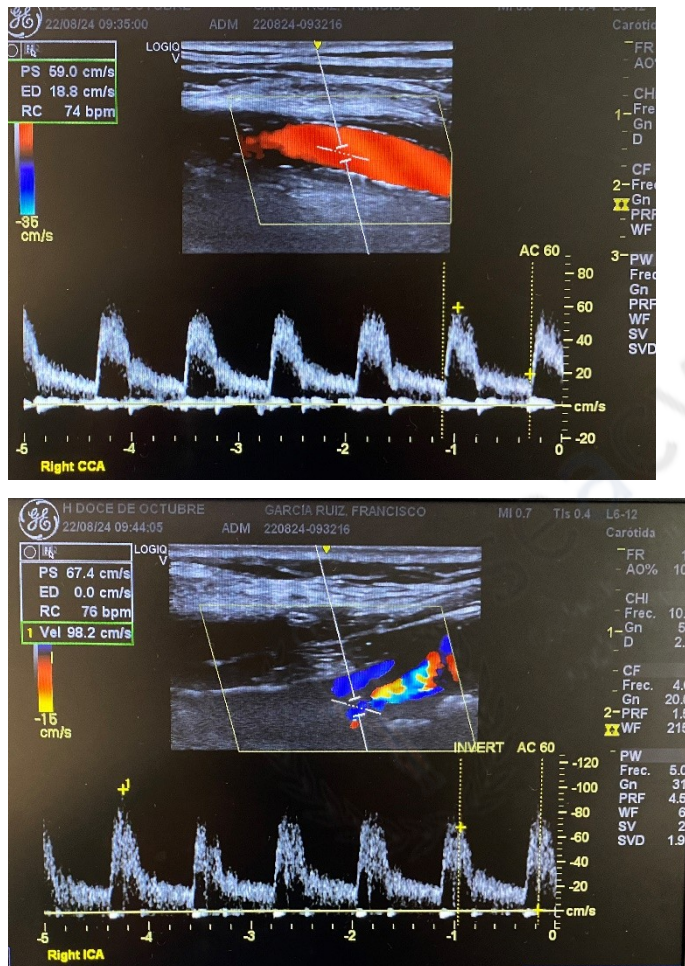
Doppler ultrasound control after CCA stent placing. Shows a patent stent with normalization of speed on the CCA and ICA.
